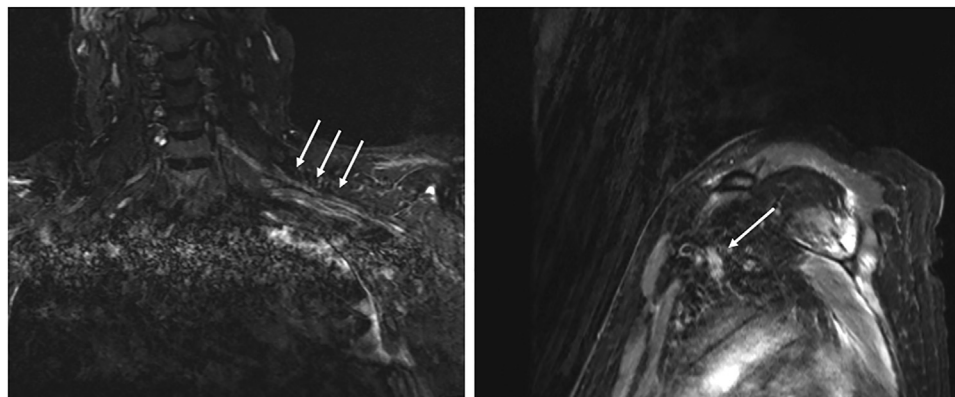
MRI of 46 year old male with 9 month history of bilateral brachial pan-plexopathy following COVID-19 infection with protracted hospital course including management in prone positioning for ARDS
